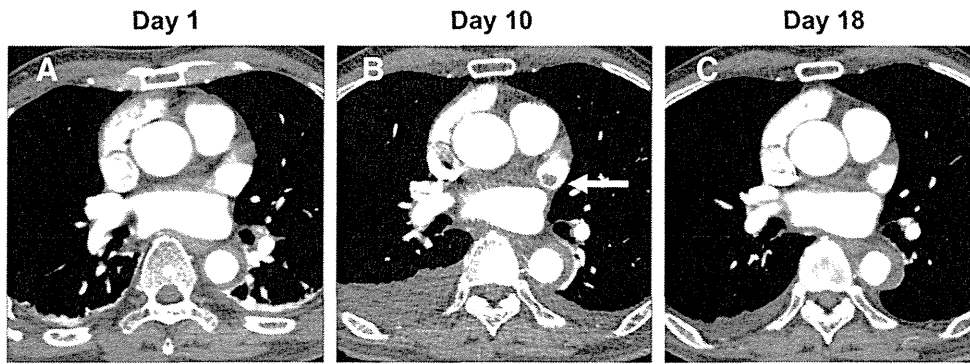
Contrast-enhanced computed tomography showing thrombus in the LAA (B, arrow) on day 10 after AAD, which was not observed on admission (A). C, After resumption of anticoagulation therapy, LAA thrombus disappeared on day 18.
